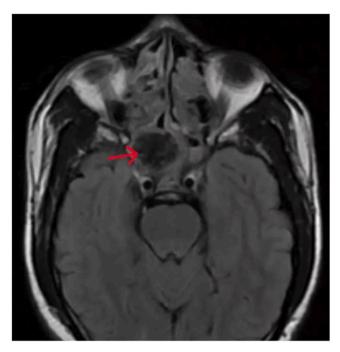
MRI brain demonstrating invasive sinusitis with abscess formation (arrow).
